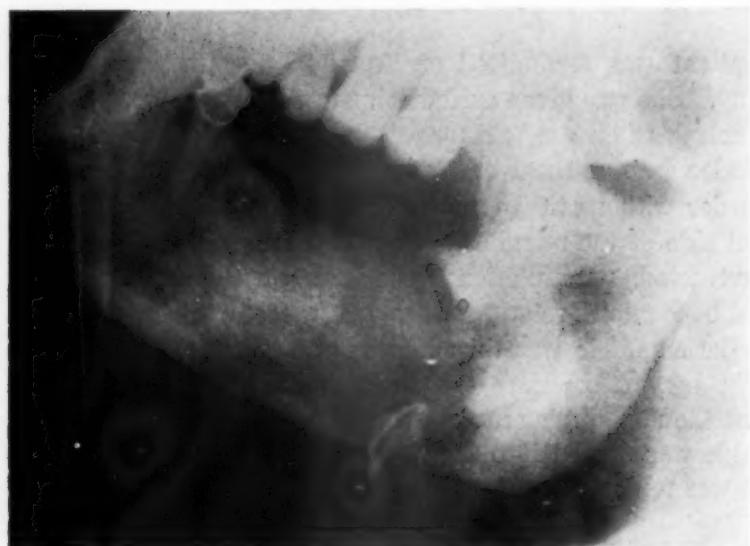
Immediate postoperative x-ray film with Dakin's tube in place.
